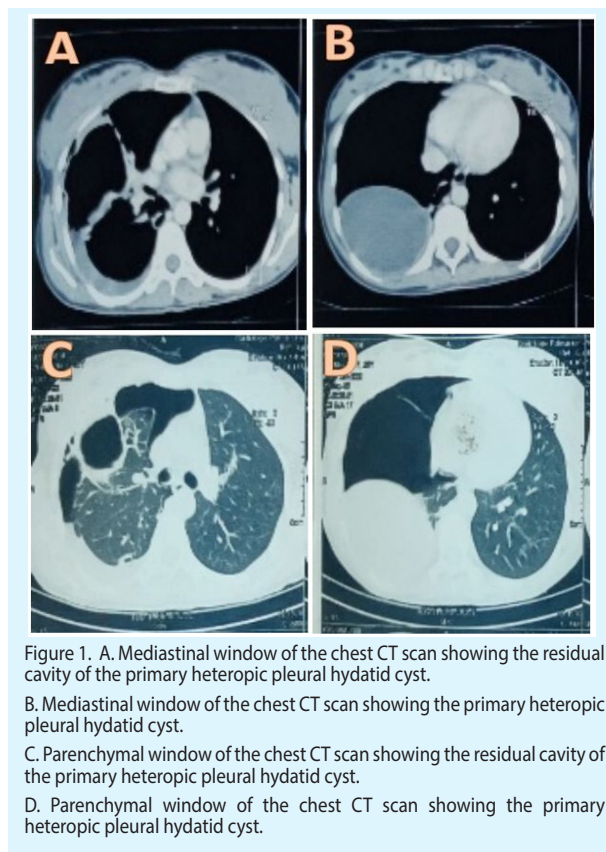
A. Mediastinal window of the chest CT scan showing the residual cavity of the primary heterotopic pleural hydatid cyst.
